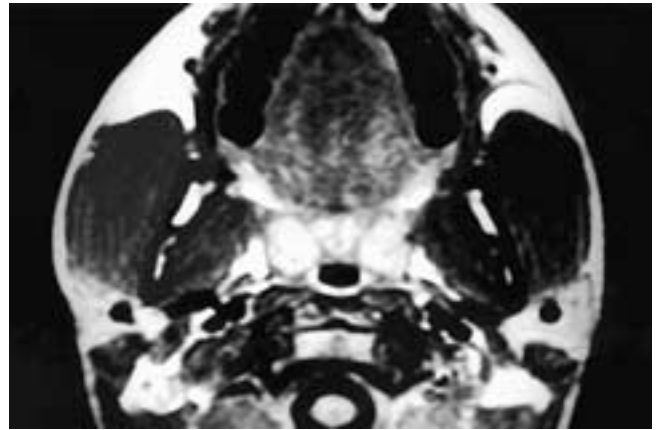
Axial T2-weighted MR image shows bilateral enlargement of the masseter muscles. The internal pterygoid muscles may also be slightly enlarged. This patient had bilateral masseteric (masticator) muscle hypertrophy.
